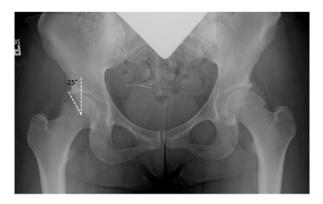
The AP, Dunn lateral, and false-profile are common radiographic views used to evaluate the hip joint. The AP radiograph demonstrates a center edge angle of 25° on the right side, measured by taking the angle between a line drawn from the center of the femoral head to the lateral edge of the acetabulum and a perpendicular line from the center
